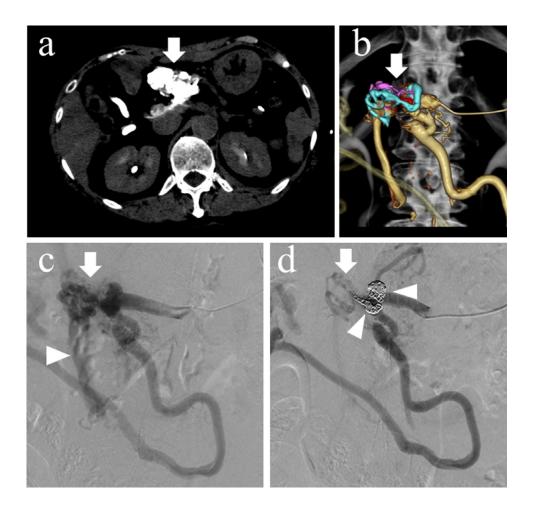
Computed tomography during venography (CTV) and angiography. (a) CTV showing the varices in the elevated jejunum (white arrow). (b) Three-dimension reconstructed image created from CTV showing the 3 feeding veins (blue, red, and pink). (c) Preoperative splenic venography showing the portal vein (arrowhead) through the elevated jejunal varices (arrow). (d) Postoperative splenic venography showing reduced blood flow in the varices (arrow) after the blue and red feeding veins were embolized with metallic coils (arrowheads).
